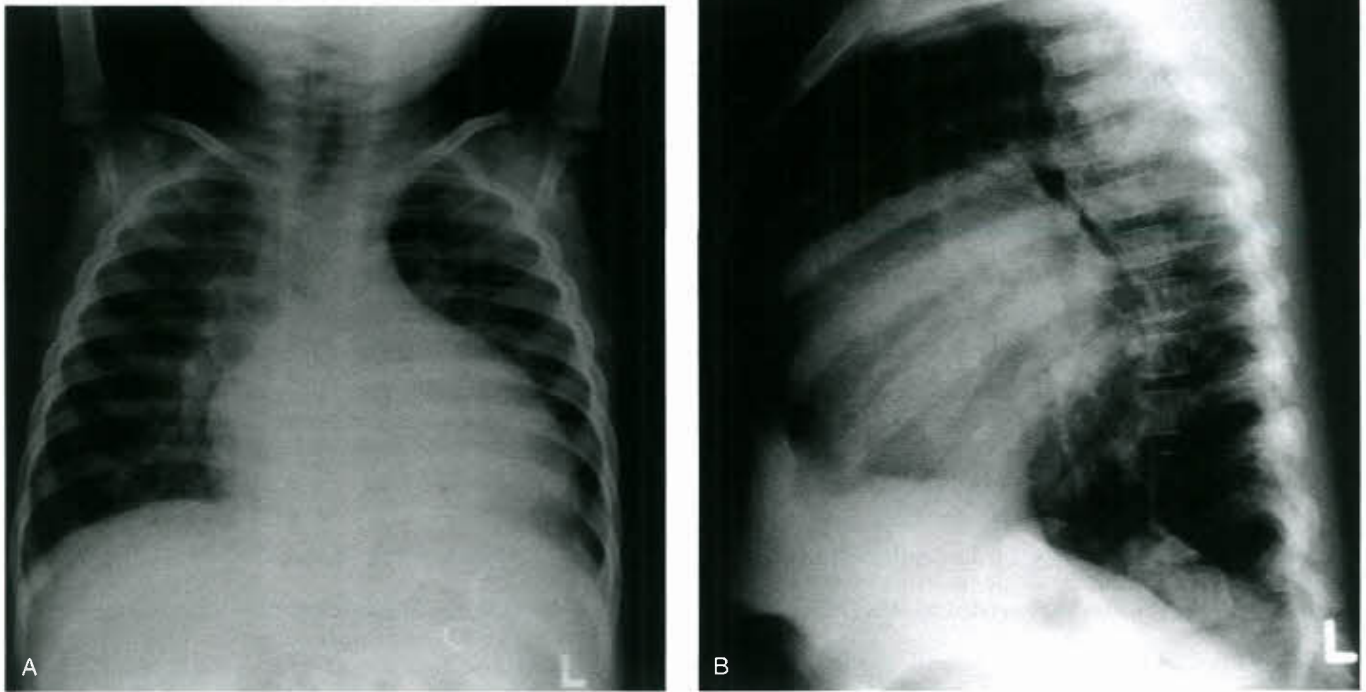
Posteroanterior (A) and lateral (B) chest roentgenograms of the same patient shown in Figure 55.3, demonstrating marked cardiomegaly, elevated left mainstem bronchus from left atrial enlargement, and pulmonary congestion.
